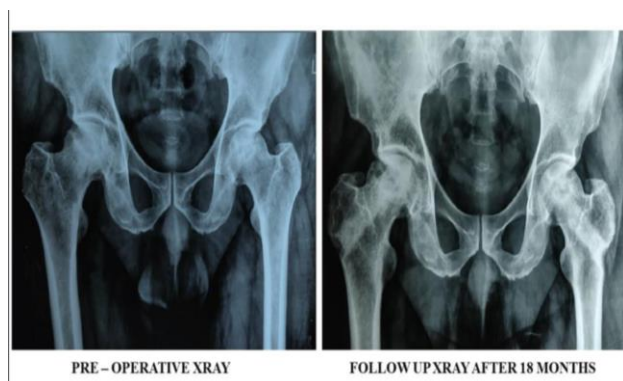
The preoperative and the postoperative X-ray with maintained sphericity of the femoral head.
